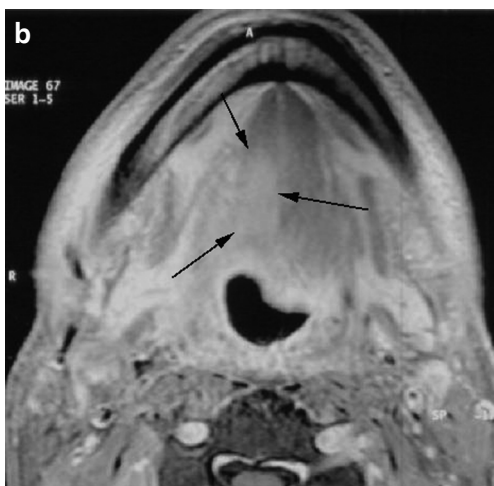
Example of grade 2a posttreatment MRI. (a) Contrast enhanced, pretreatment MRI image (T1-weighted) at the level of the tongue base showing the primary oropharyngeal tumor measuring 40 x 29 mm. (b) Contrast-enhanced, posttreatment MRI image (T1-weighted) of the same patient at the same level as figure 3a, suggesting a residual mass of 19 x 15 mm, which was graded 2a. Biopsies taken 8 weeks after treatment were negative. The primary tumor did not recur during a 3-year follow-up period.
